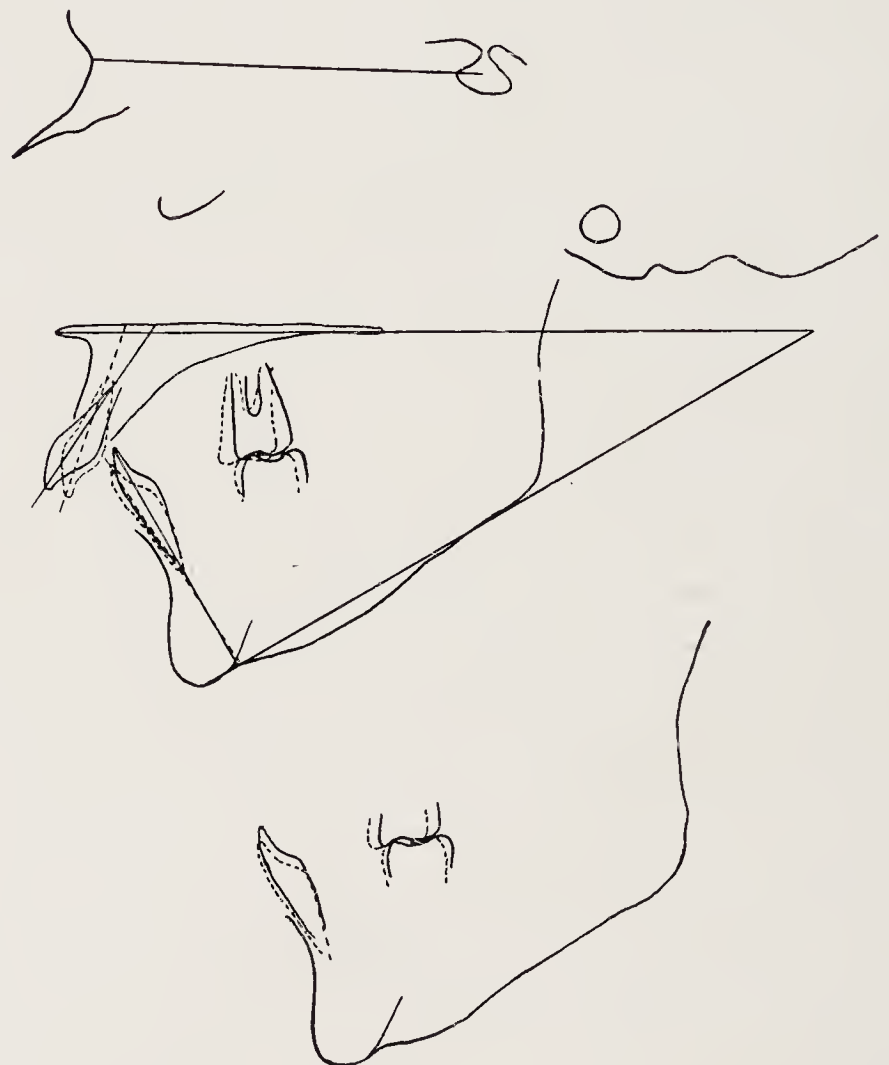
Case 2. Tracings of lateral skull radiographs, superimposed on S-N plane, and, the lower, tracings of the mandibles superimposed, showing depression of the lower incisors by means of multi-banded appliances.
